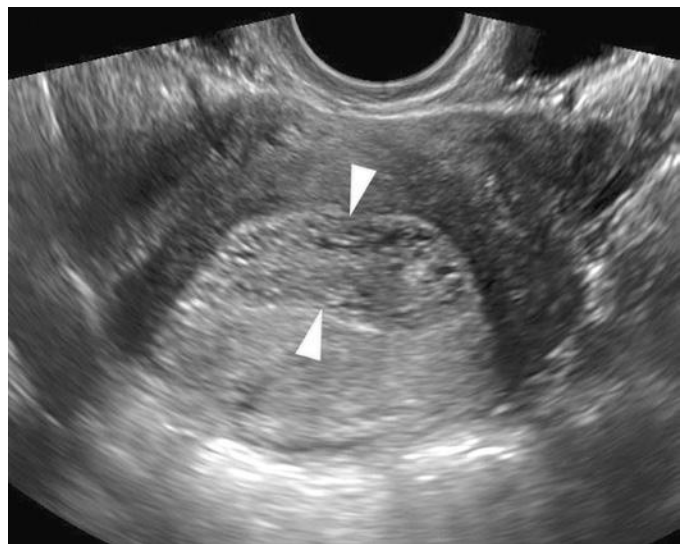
A 41-year-old woman with menorrhagia. Transverse transvaginal sonography shows diffuse thickening of the endometrium (arrowheads) with internal areas of cystic change resulting in the typical "swiss cheese" appearance of endometrial hyperplasia.
